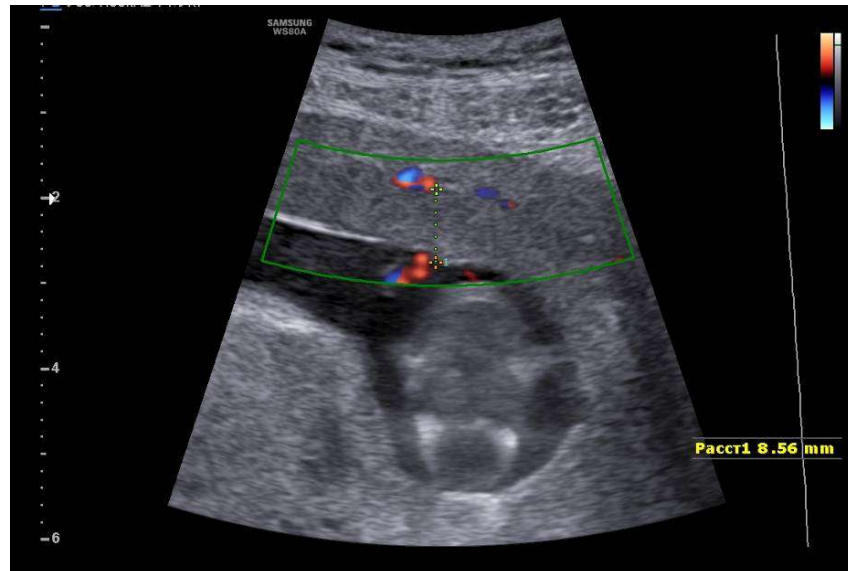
Color dopplerography. Thinning of the placenta and reduction of its volume in a woman with adenomyosis group All with traditional methods of pregnancy management at 12 weeks of gestation.
